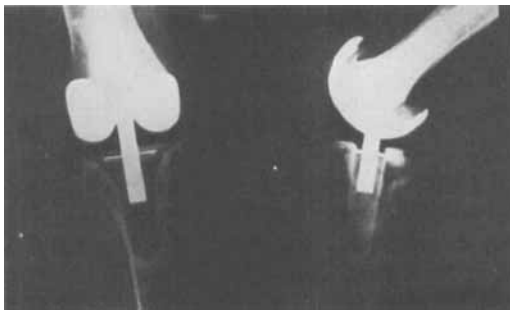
X-rays at follow-up: The same knee as above 2 years postoperatively. The patient had no pain at all. She was able to walk at least 2 kilometres without any walking aid. There was neither residual angulation or instability of the knee nor subluxation of the patella. The functional score at follow-up was 95 points.
